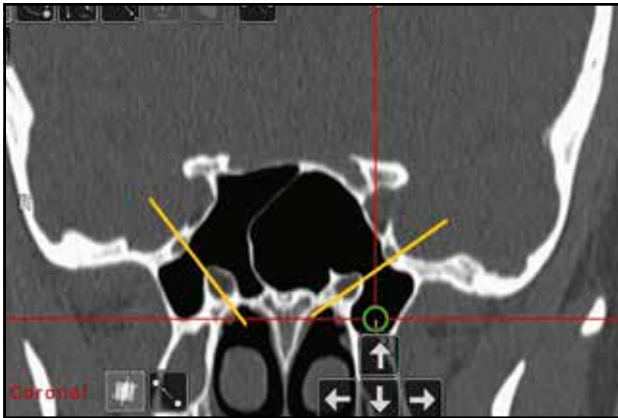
Pterygoidian extension - situated under the level of the vidian canal (green circle) and into the pterygoidian process (cranio-facial CT scan, coronal slice; yellow line – along the vidian canal and the medial margins of the foramen rotundum).
